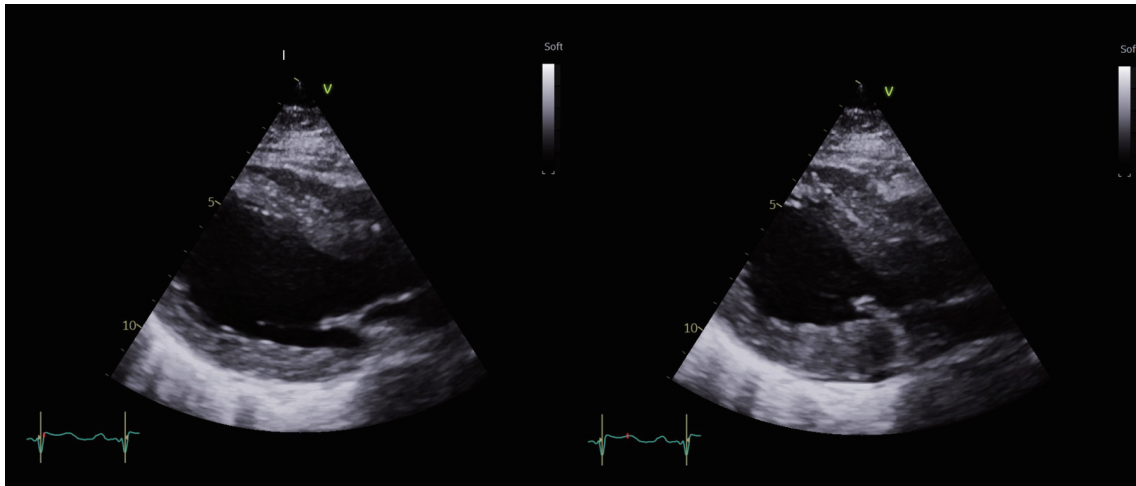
Echocardiogram showing apical ballooning and dilation, with basal segment contraction.
